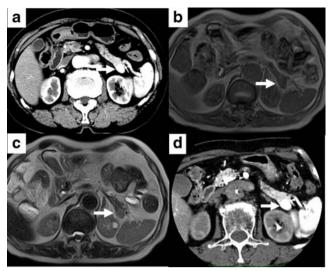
a Enhanced CT showed a well-defined, homogeneously enhanced tumor, about 1 cm in size, in the tail of the pancreas (*arrow*). b MRI revealed isointensity on T1-weighted images (*arrow*). c MRI showed iso to high intensity on T2-weighted images (*arrow*). d CT angiography showed strong enhancement (*arrow*).
